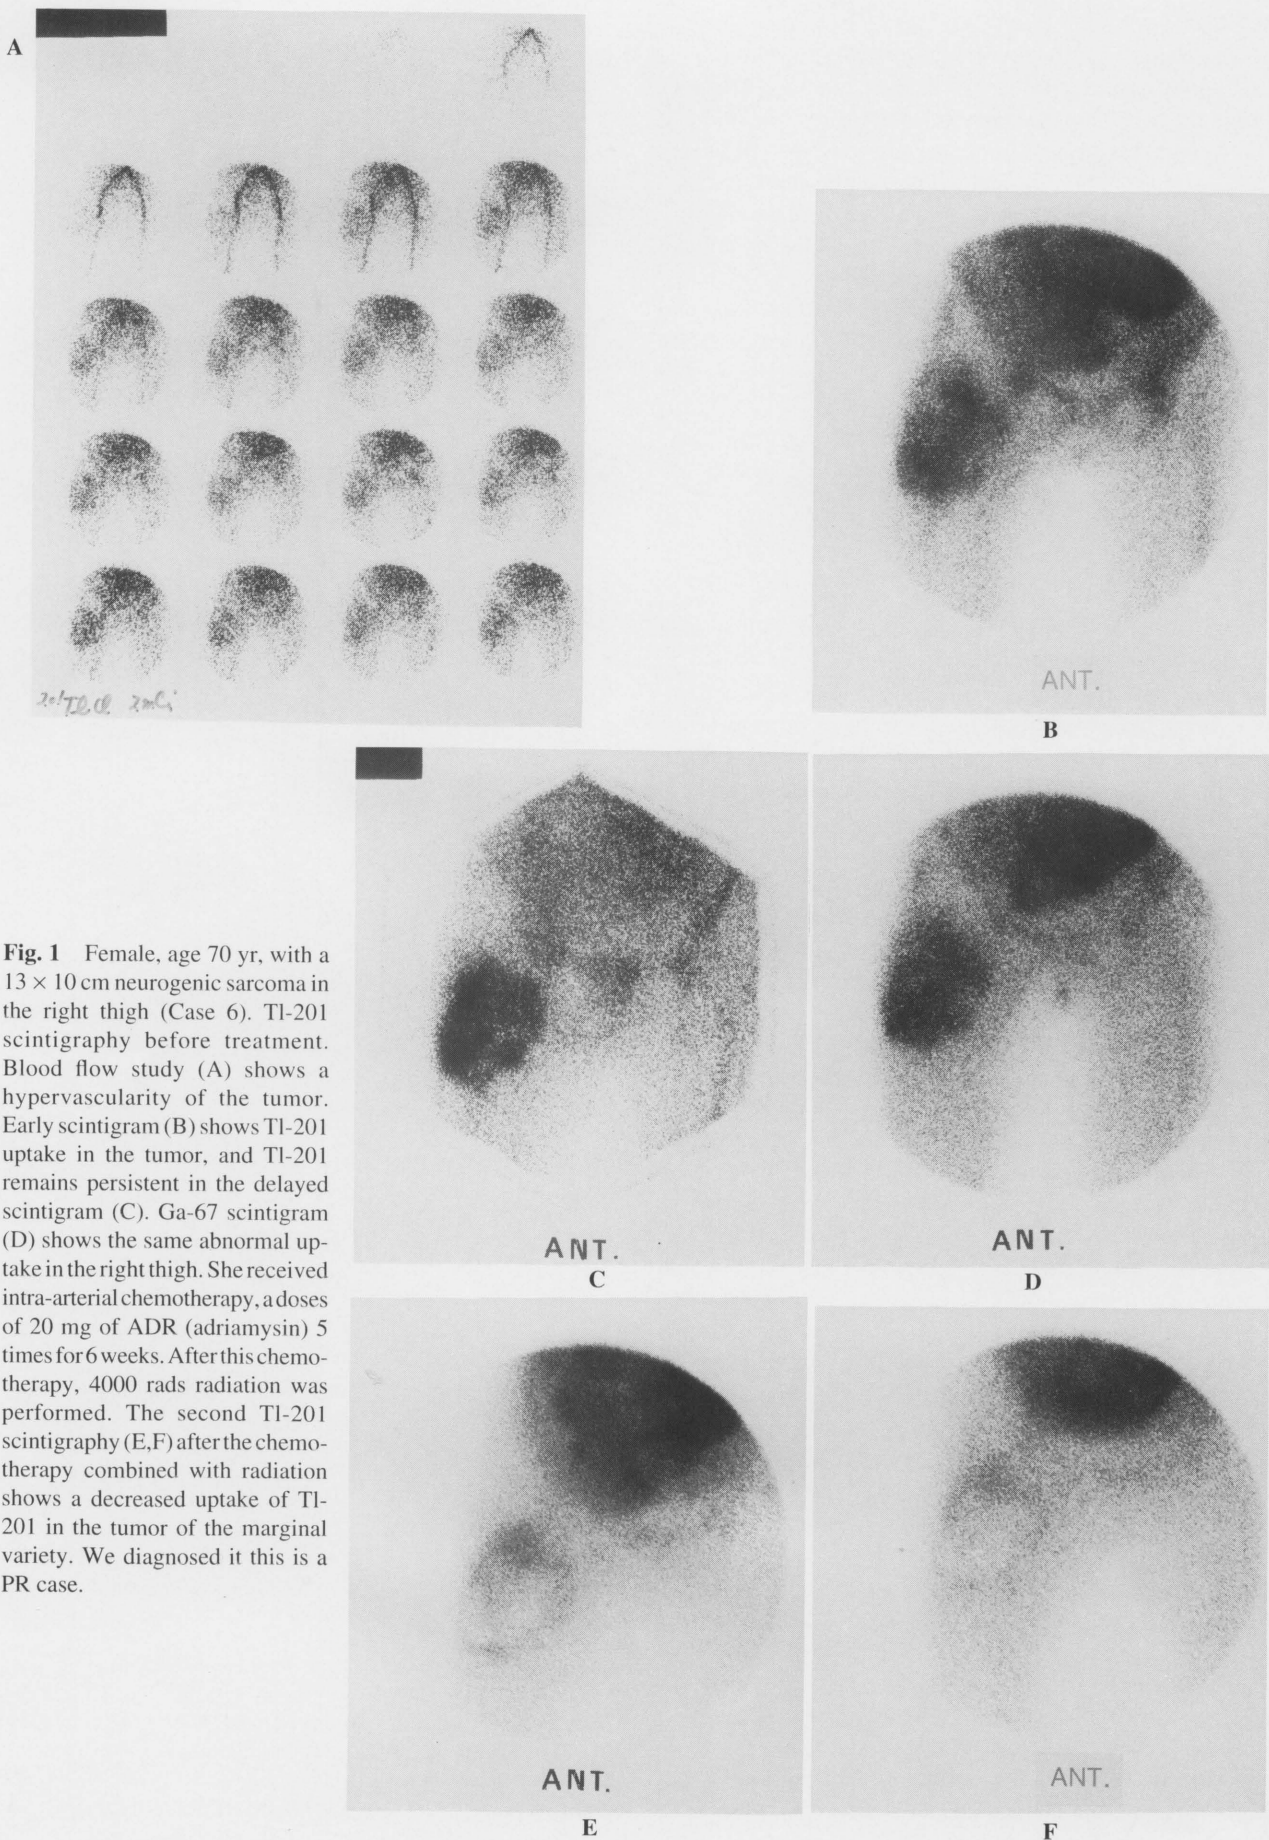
Female, age 70 yr, with a 13×10 cm neurogenic sarcoma in the right thigh (Case 6). Tl-201 scintigraphy before treatment. Blood flow study (A) shows a hypervascularity of the tumor. Early scintigram (B) shows Tl-201 uptake in the tumor, and Tl-201 remains persistent in the delayed scintigram (C). Ga-67 scintigram (D) shows the same abnormal uptake in the right thigh. She received intra-arterial chemotherapy, a doses of 20 mg of ADR (adriamycin) 5 times for 6 weeks. After this chemotherapy, 4000 rads radiation was performed. The second Tl-201 scintigraphy (E,F) after the chemotherapy combined with radiation shows a decreased uptake of Tl-201 in the tumor of the marginal variety. We diagnosed it this is a PR case.
